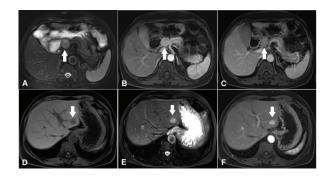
Magnetic resonance images of the whole abdomen, axial T2-weighted (A) fat-suppressed images, axial arterial phase, (B) and PVP (C) T1-weighted fat-suppressed image demonstrates a mildly lobulated, slightly hyperintense mass (arrow) epicentered between the duodenum and superior aspect of the pancreatic head. The mass exhibits enhancement on the arterial phase and washout on the portovenous phase. Axial T1-weighted (D), T2-weighted (E), fat-suppressed image and axial arterial phase T1-weighted image (F), and hyperintense liver mass (arrow) with arterial enhancement. Increased gastric rugal folds and mild gastric wall thickening was noted.
